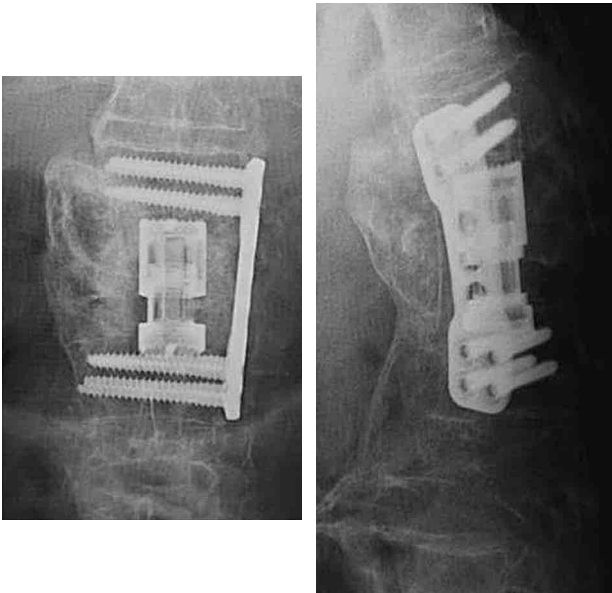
Postoperative plain radiographs showing improved local kyphosis (Cobb angle : 17°).
